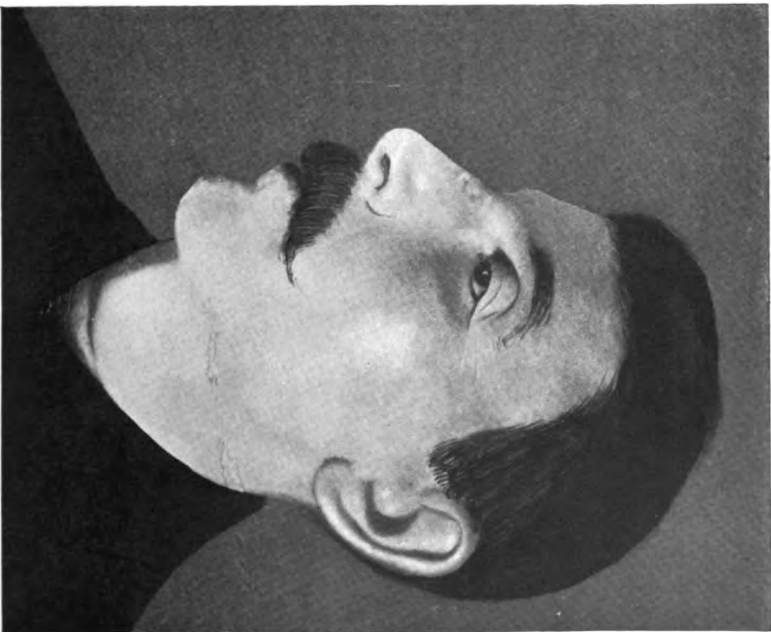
Result of x-ray treatment of patient shown in FIG. 34.
